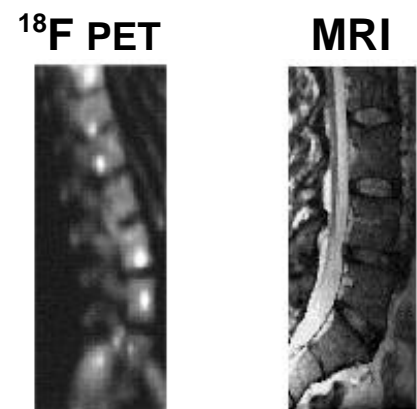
Vertebrae and spinal cord images. PET image shows metastatic tumors, from higher uptake of FDG
